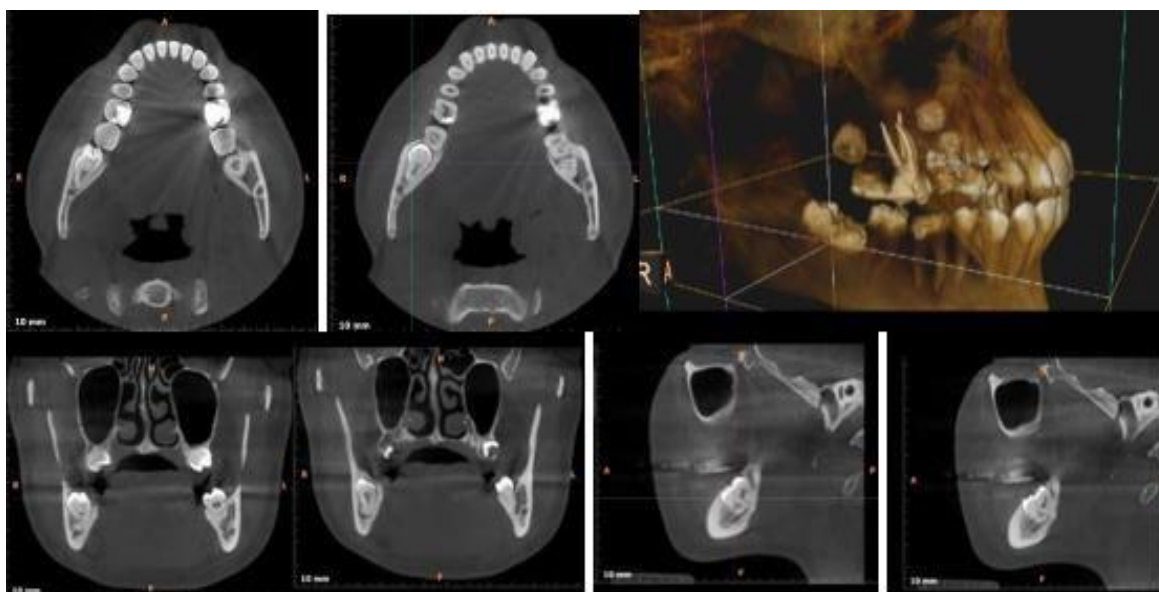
CBCT. Showing axial, Coronal, Sagittal and Dimensional View.
